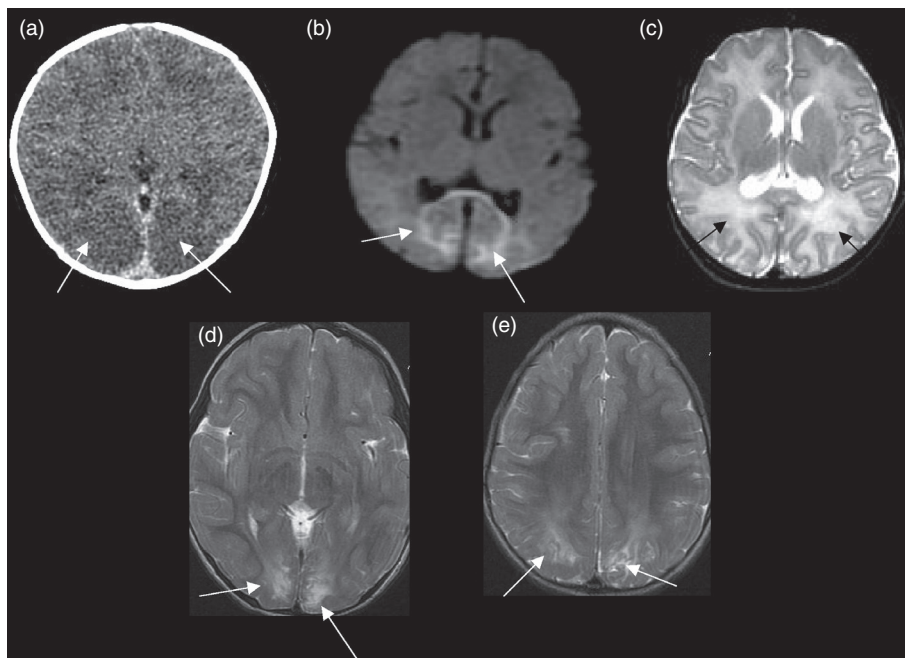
Hypoglycemia with parieto-occipital involvement (arrows) in the subacute phase with edema as (a) low density on CT, and as high intensity on (b) DWI and (c) T2 MRI; also (d,e) the chronic phase with atrophy and gliosis on T2 MRI.
